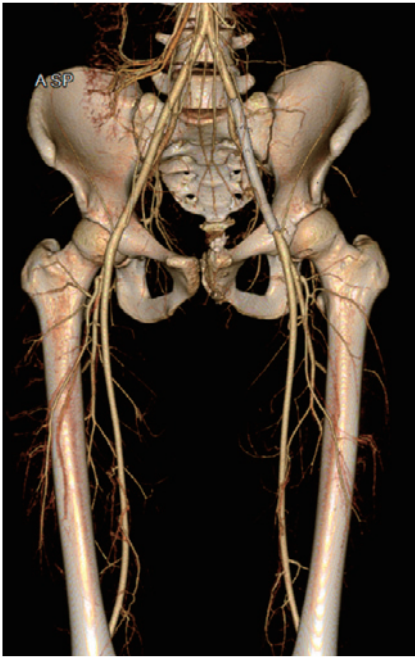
A 3-dimensional, contrast-enhanced CT scan on postoperative day 90 shows no residual stenosis and favorable peripheral blood flow.
